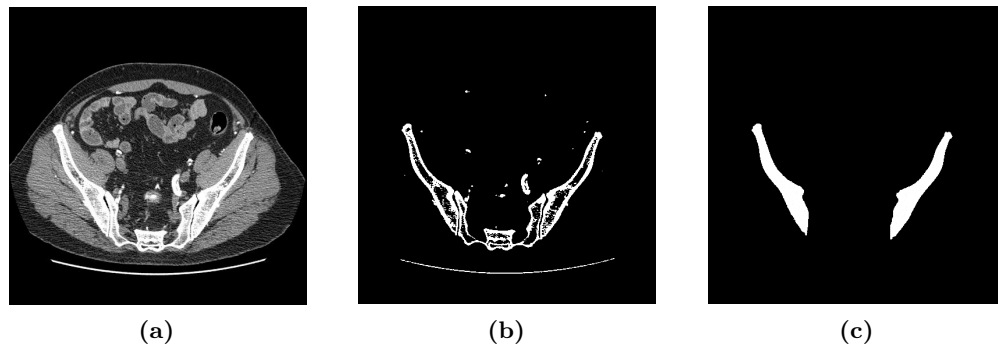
The patient CT segmentation process (a) The original Dicom slice image (b) The thresholded slice image and (c) The cleaned slice image.
